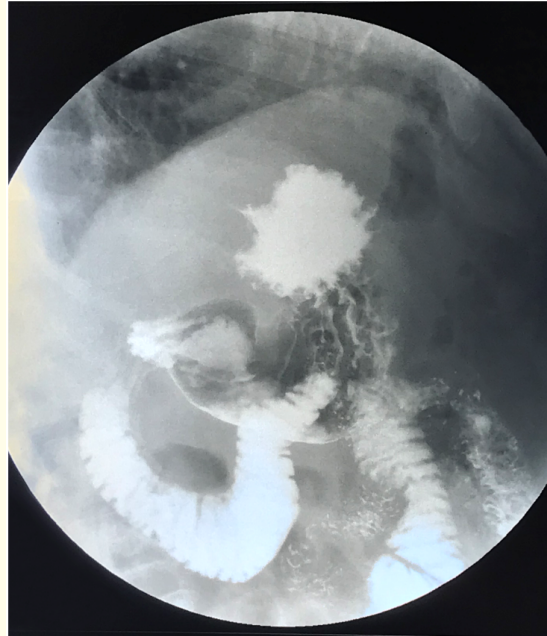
X-ray contrast examination in Trendelenburg position. The antireflux wrap prevents gastroesophageal reflux.
